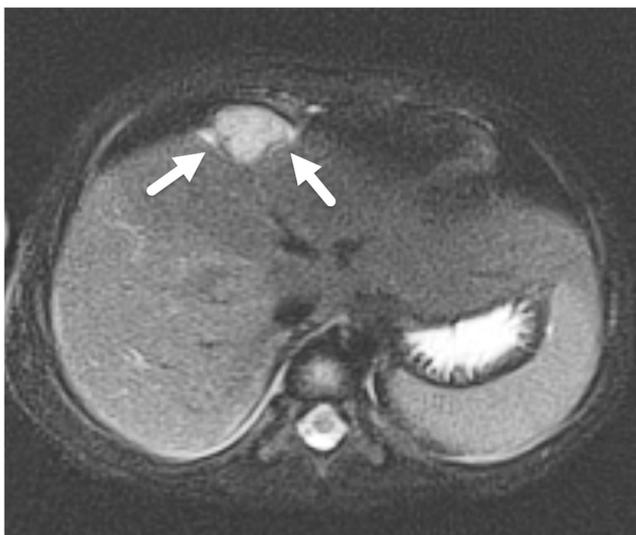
Tumor surrounded by normal tissue. Axial T2-weighted MRI in a child with hepatoblastoma shows extrahepatic/peritoneal spread of tumor (arrows). The tumor, a diaphragmatic metastasis, is surrounded more than 180° by a small amount of fluid and normal liver. A clear plane is seen between the tumor and the liver
